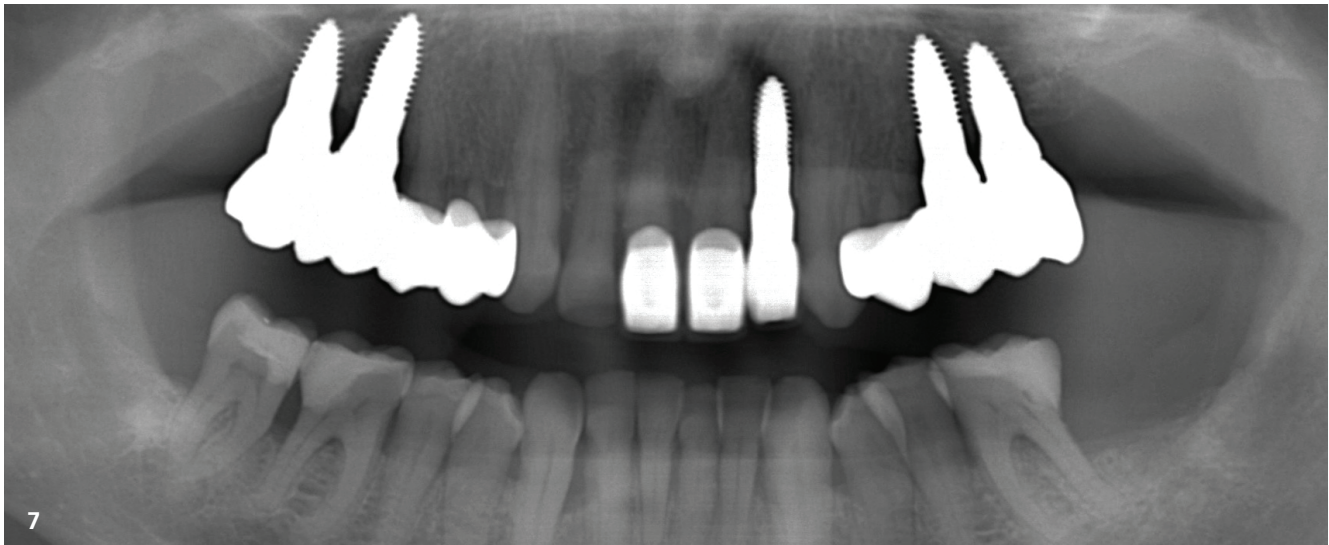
Radiograph taken with the restoration in place.
